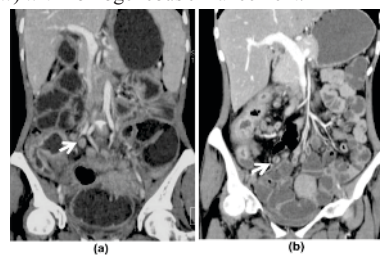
Regional lymphadenopathy in ileocaecal tuberculosis. (a) Coronal CT image shows discrete homogeneous lymph nodes in the mesentery (arrow). (b) Coronal CT image shows discrete necrotic lymph nodes in the mesentery (arrow) in another patient.
